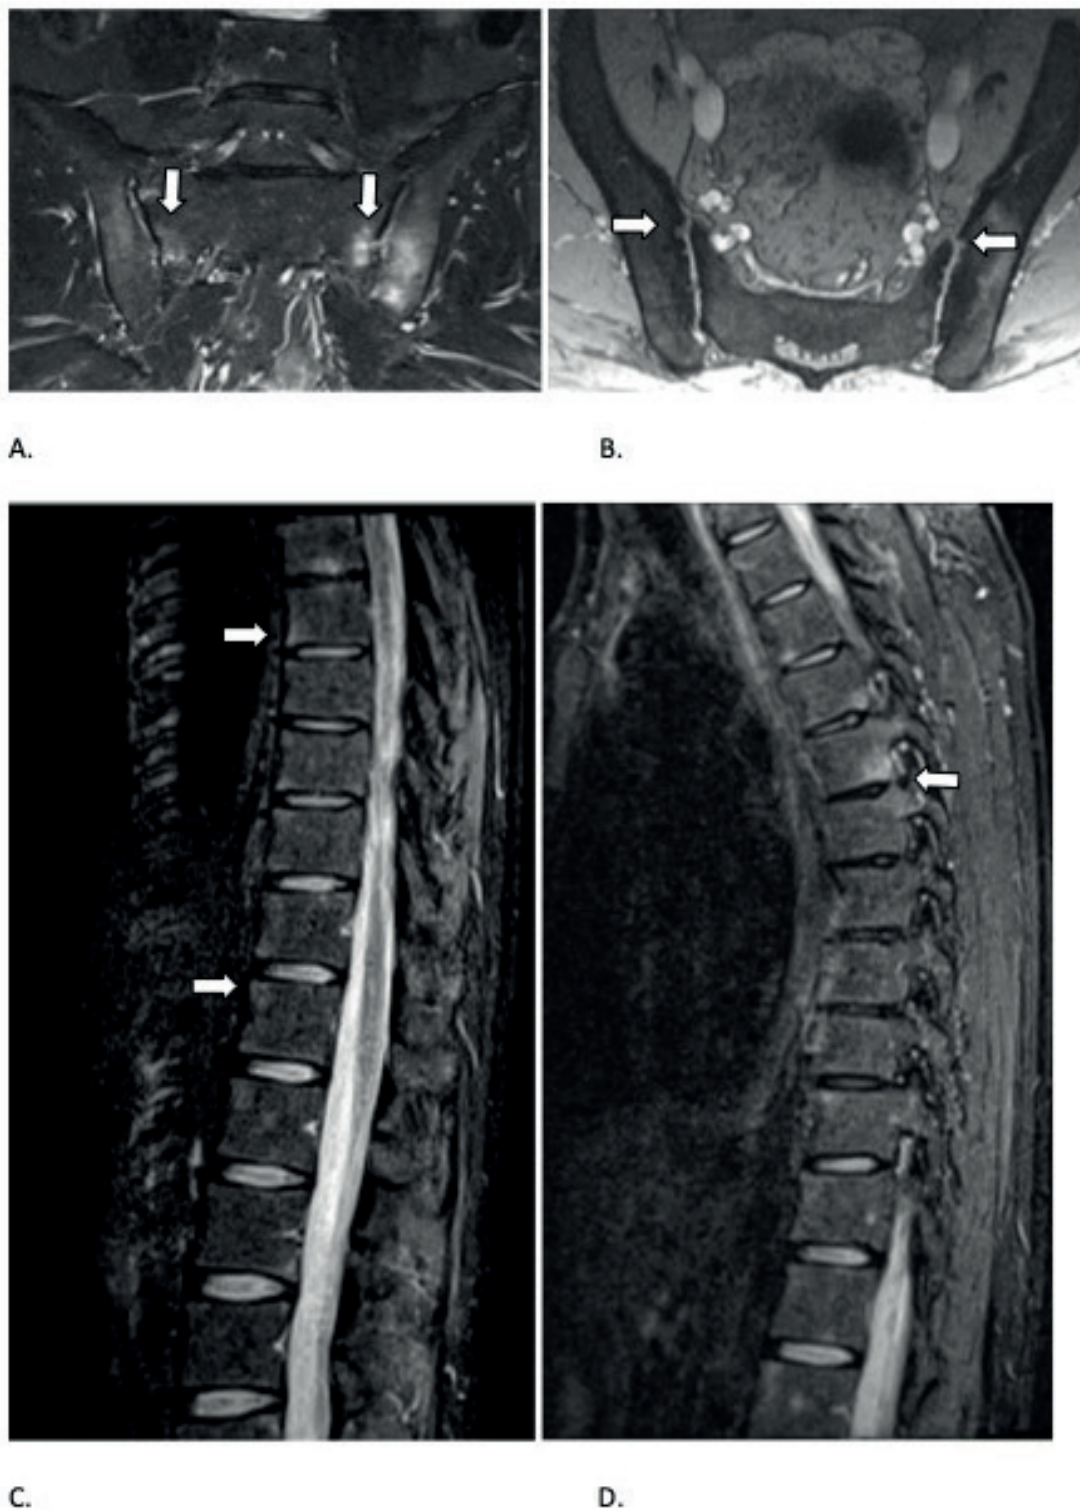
MRI thoracic spine and sacroiliac joints TRIM sag and cor., T2 me 2D ax. Bilateral sacroiliitis with bone marrow edema (picture A), subchondral erosions (picture B) and multisegmental bone marrow edema at the anterior and dorsal corners of the vertebrae (picture C and D) as a sign of early, active spondylitis.
